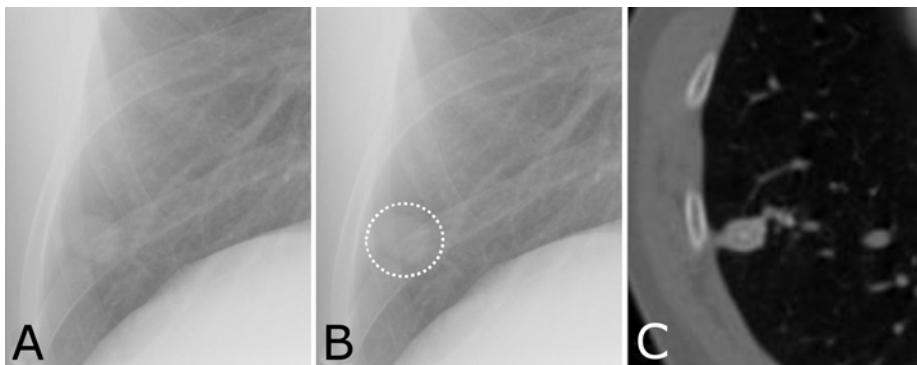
Solitary pulmonary nodule with a benign pattern of calcification. A. Unmarked film. B. Marked film to show the solitary pulmonary nodule. It could not be determined from the film if the nodule was calcified or not. C. Axial CT image demonstrates a central calcification, indicating this nodule represents a benign granuloma and requires no further evaluation.
